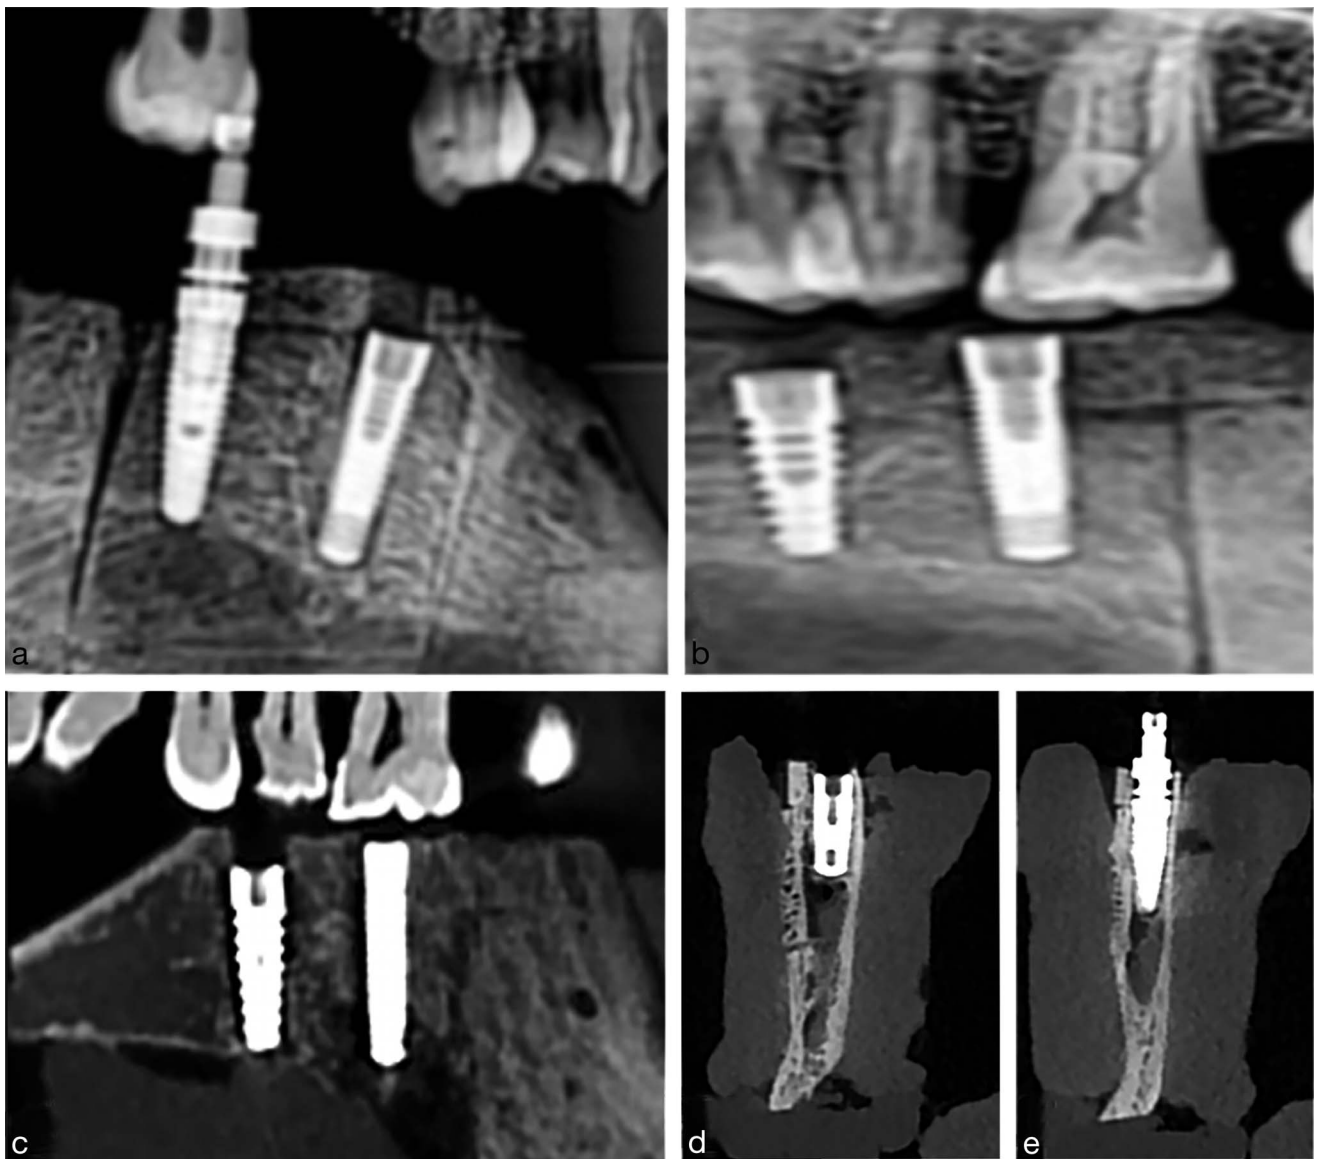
(a) Pilot drill injury (left) and collapsing of the superior border of the inferior alveolar canal (right) in standard panoramic radiography. (b) Images taken with the dentition mode of the panoramic radiography showing pilot drill injury (left) and control samples with no damage (right). (c) Pilot drill perforation (left) and collapsing of the canal border (right) in the multiplanar reconstructed image from sagittal plane. (d) The cross-sectional image of collapsing of the cortical border and the penetration of the implant tip into the inferior alveolar canal (e).
